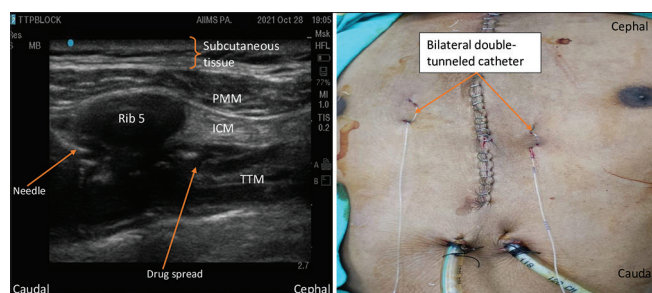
Ultrasound-guided continuous transversus thoracic plane block. PMM: Pectoralis major muscle, ICM: Intercostal muscle, TTM: Transverses thoracic muscle
